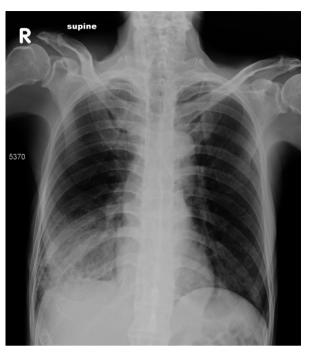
Chest X-ray showed right lower lung infiltrates, compatible with pneumonia.
